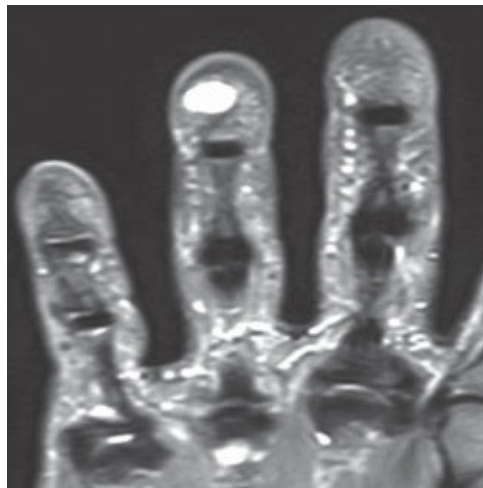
• MRI of glomus tumor of the ring finger. Note the high signal intensity of the tumor.
